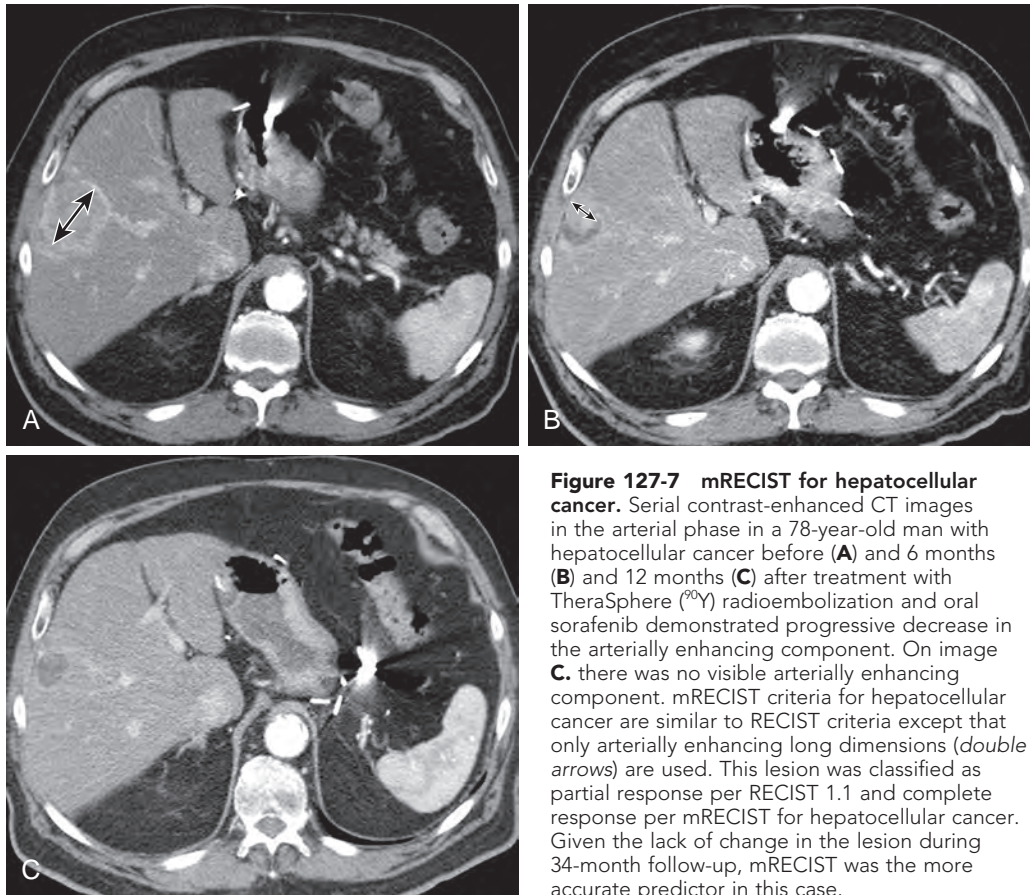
mRECIST for hepatocellular cancer. Serial contrast-enhanced CT images in the arterial phase in a 78-year-old man with hepatocellular cancer before (A) and 6 months (B) and 12 months (C) after treatment with TheraSphere (^{90}Y) radioembolization and oral sorafenib demonstrated progressive decrease in the arterially enhancing component. On image C, there was no visible arterially enhancing component. mRECIST criteria for hepatocellular cancer are similar to RECIST criteria except that only arterially enhancing long dimensions (double arrows) are used. This lesion was classified as partial response per RECIST 1.1 and complete response per mRECIST for hepatocellular cancer. Given the lack of change in the lesion during 34-month follow-up, mRECIST was the more accurate predictor in this case.
